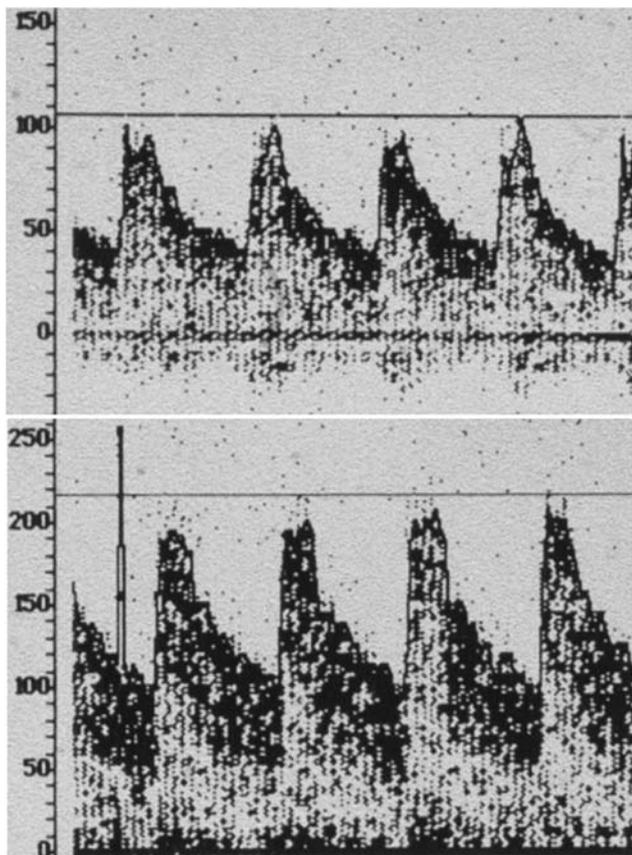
Graphical representation of the effect of changes in intracranial pressure (ICP) on the transcranial Doppler waveform appearance. The top waveform is an example of a normal pulsatility index (PI) of roughly 0.7, and ICP of 5 to 10 mm Hg. The bottom waveform is an example of a moderately raised ICP with PI 1.2.
